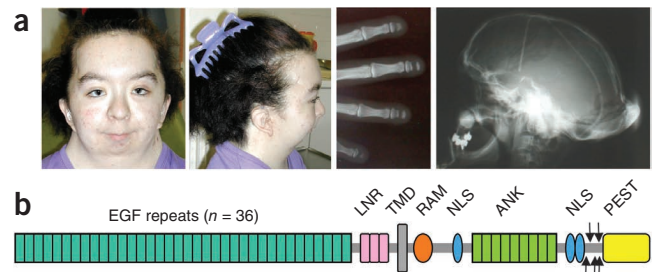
Identification of *NOTCH2* mutations in individuals with Hajdu-Cheney syndrome. (a) Facial dysmorphism of individual F2-II-2 with micrognathia, thick eyebrows, long philtrum, hypertelorism, and low-set and posteriorly rotated ears. We obtained written consent to publish photographs of this individual. Phalanges radiograph of individual F5-II-2 showing acro-osteolysis of all distal phalanges. Skull radiograph of individual F4-II-1 showing characteristic findings of HCS, including platybasia, thickened occipital bone, open sutures and wormian bones. (b) Predicted protein domains of *NOTCH2*. The black arrows indicate the location of the truncating mutations identified in the five families with HCS. EGF, epithelial growth factor; LNR, cysteine-rich Lin12-Notch repeats; TMD, transmembrane domain; NLS, nuclear localizing domain; ANK, ankyrin repeats; PEST, domain containing conserved proline-glutamic acid-serine-threonine-rich motifs.
